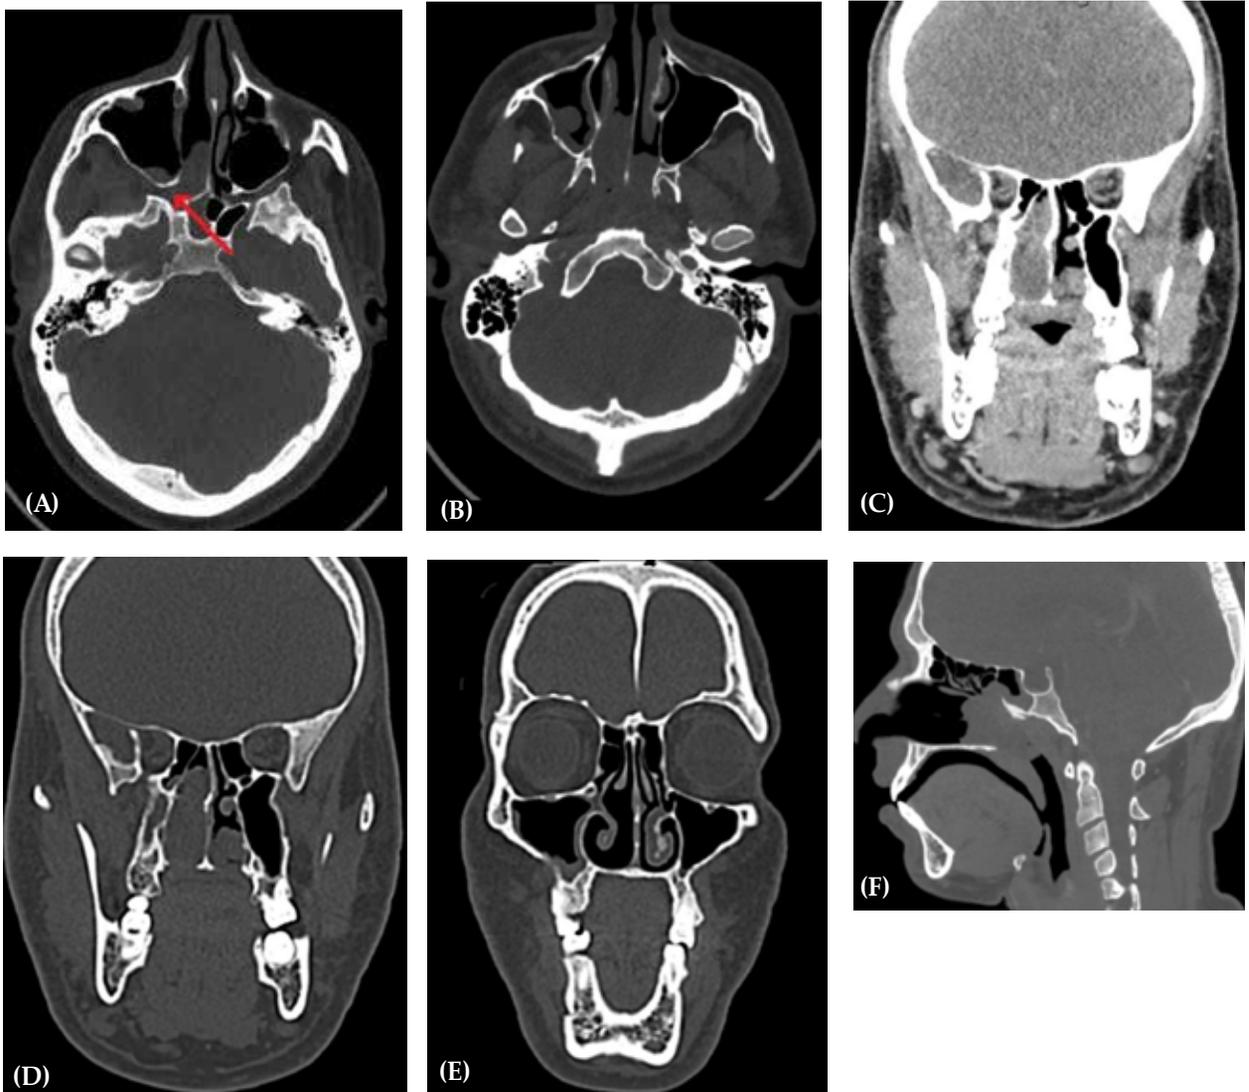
Computed tomography scan with contrast revealed non-enhancing soft tissue density in posterior end of the right nasal cavity extending into both choana with widening and hyperostosis of the right sphenopalatine foramen (red arrow) (A,B,C,D). Ipsilateral maxillary and sphenoid sinuses are only partially opacified (E,F).
